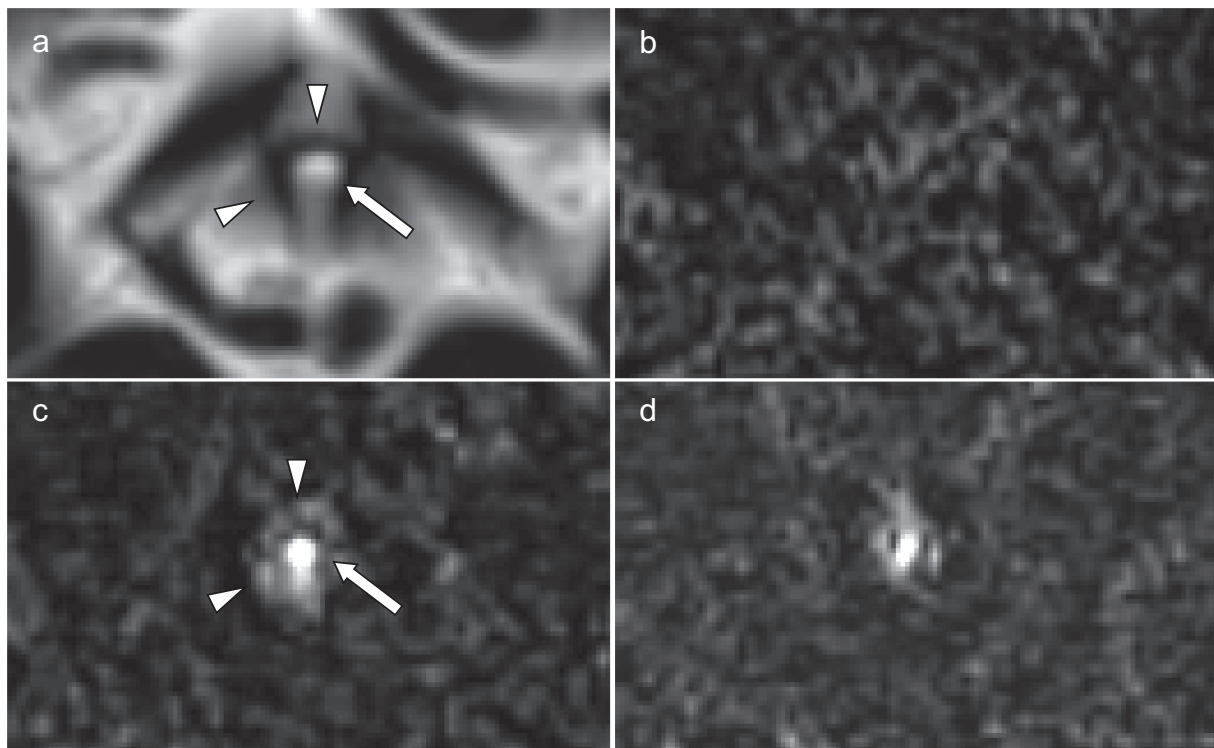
Contrast enhancement of the median eminence. The infundibular recess (a, arrow) is surrounded by the median eminence (a, arrowheads) on MRC. On HT2-FLAIR, in comparisons with a precontrast image (b), a postcontrast image (c, arrow) shows stronger contrast enhancement of the infundibular recess. The median eminence shows weaker contrast enhancement than the infundibular recess (c, arrowheads). A 4-h delayed postcontrast image (d) shows decreases in contrast enhancement of the infundibular recess and median eminence. 4-h, 4-hour; HT2-FLAIR, heavily T2-weighted 3D fluid-attenuated inversion recovery; MRC, MR cisternography.
